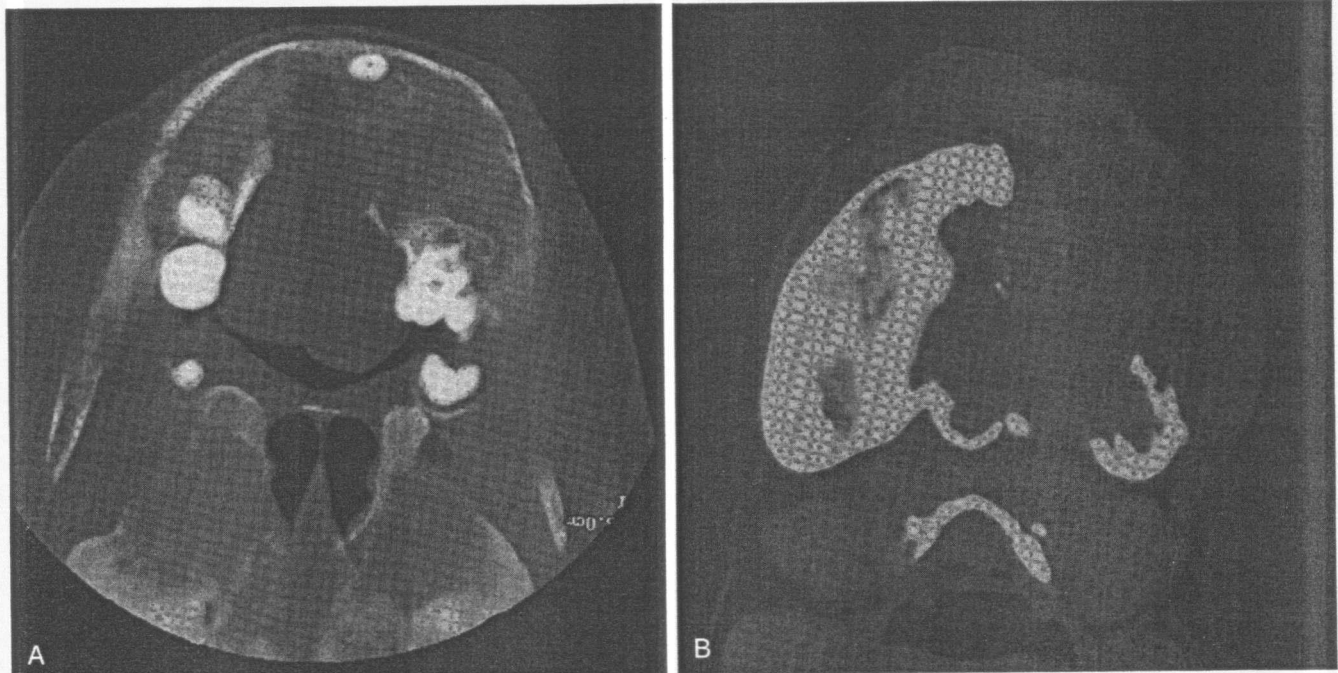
Computed tomographic scans of the mandible of an 11-year-old girl with McCune-Albright syndrome who developed a sarcoma in a preexisting FD lesion. *A*, Scan (bone window) of the mandible performed in 1998 demonstrating typical ground-glass appearance of FD. *B*, The same area 1 year later (soft tissue window) demonstrating loss of the bone cortex and an expansile soft tissue mass.
